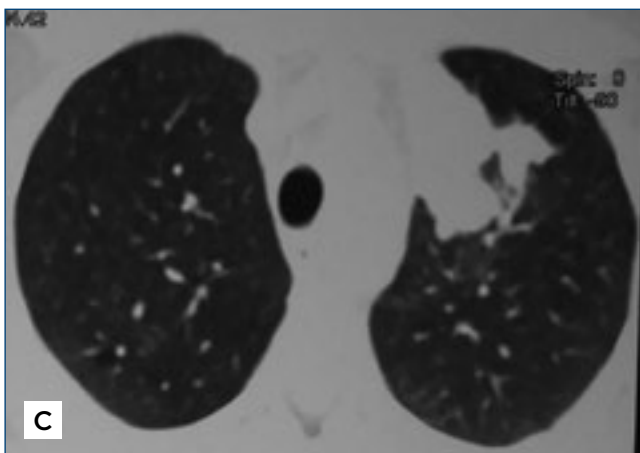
Computed tomography of the chest (follow-up): A, B (June 2013) with bilateral opacities and ground glass; C, D (October 2013), E, F (January 2014) showing left upper lobe opacity significant extension with less ground glass
